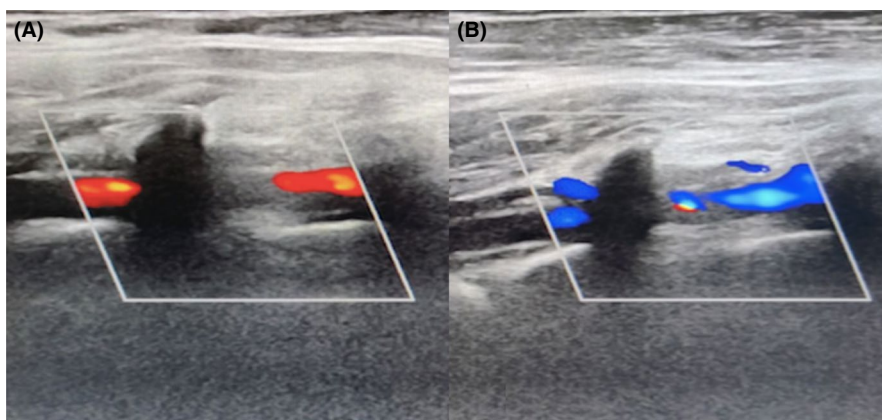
Doppler study showing complete reversal of the blood flow in the left vertebral artery. ((A) Right vertebral artery; (B) Left vertebral artery)
